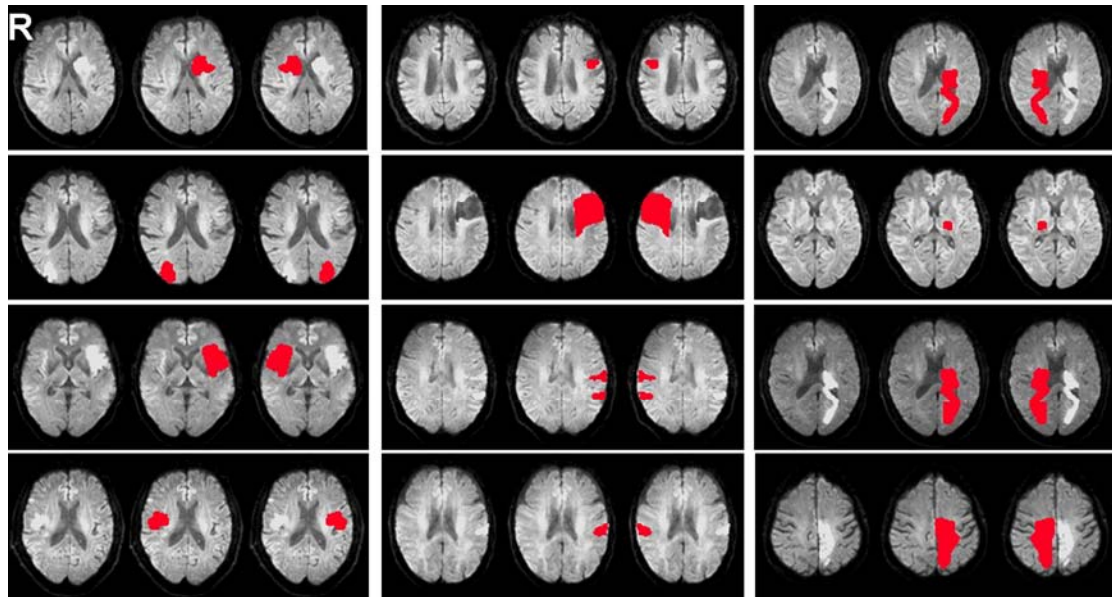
Infarct core (from DWI) and its symmetrical masks (red) of 12 stroke patients.
